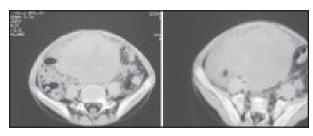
CT scans showing the tumor mass
